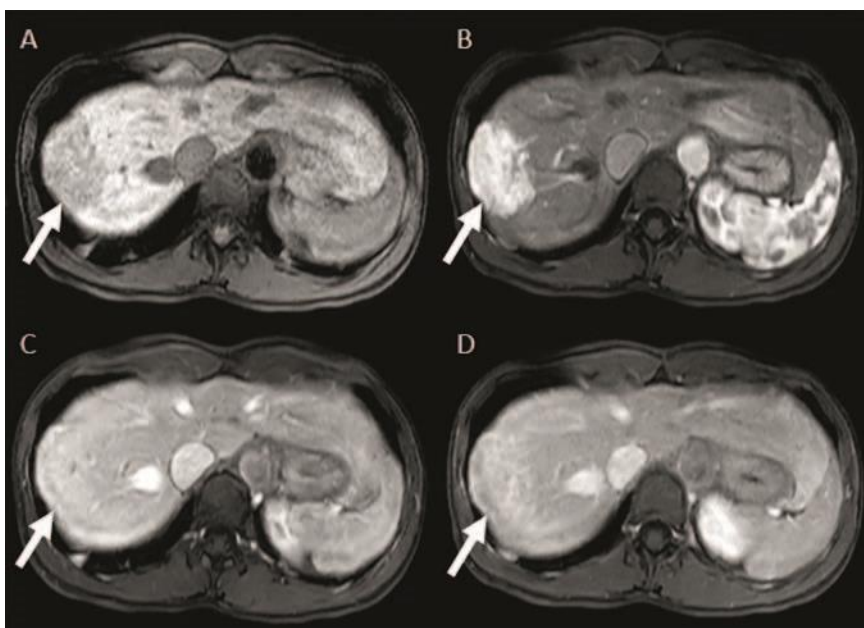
MRI of the liver. MR-images demonstrate T1-weighted native A and contrast-enhanced (B–D postcontrast dynamic) sequences in a transversal plane of 44-year old female patient with an incidental finding of a big unclear focal liver lesion at the right liver lobe. A On the native T1-weighted image the liver mass (white arrow) at the right liver lobe appears hypointense compared to the surrounding normal liver. B The liver lesion shows an intense early homogeneous contrast enhancement on the arterial phase and is more hyperintense than the liver parenchyma. C, D The liver lesion is almost isointense to the surrounding liver parenchyma on portal venous C and venous D phase with no central fibrotic scar seen. The mass cannot be clearly distinguished from the liver parenchyma.
